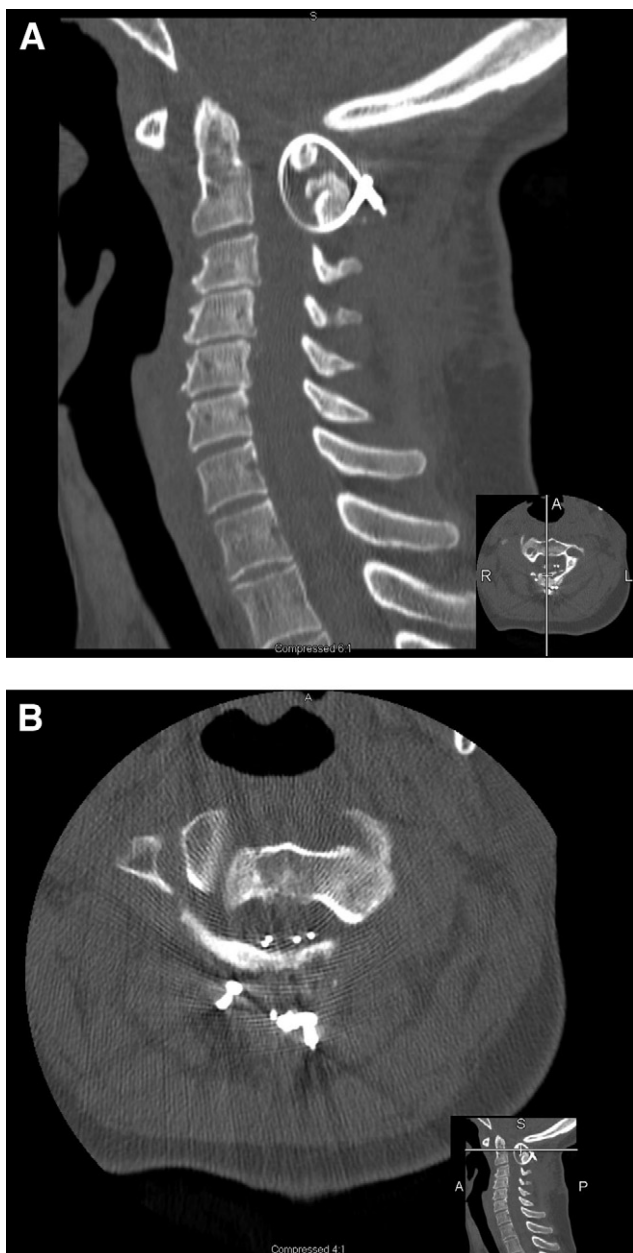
Sagittal (A) and axial (B) computed tomography images of cervical spine obtained at time of presentation to clinic.
